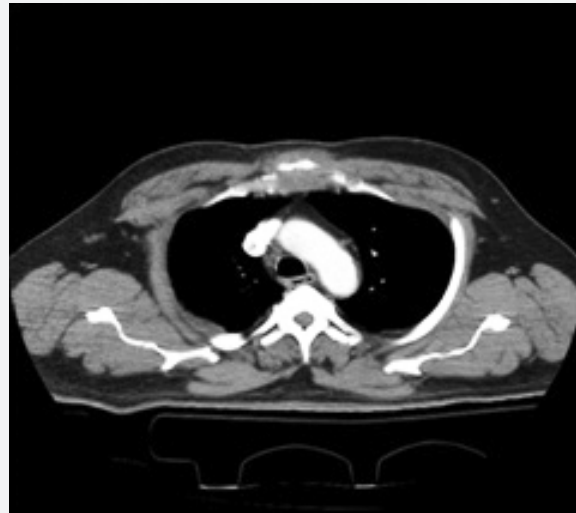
Thoracic CT showed a fracture of approximately 1 cm in size in the sternum.
